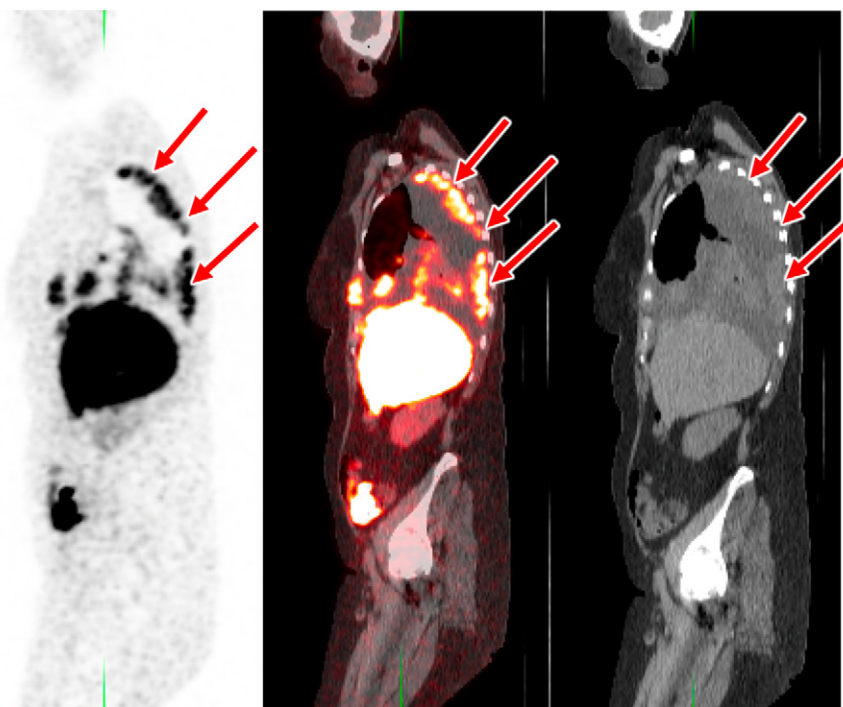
Metastatic ER-positive invasive ductal carcinoma in a 60-year-old woman who underwent mastectomy in 1993 and presented with increased chest discomfort and difficulty breathing in 2019. Sagittal FES PET (left) and fused FES PET/CT (middle) images show FES uptake in right pleural-based metastases (arrows), and sagittal CT image (right) shows a large likely malignant right pleural effusion (SUV scale, 0–5). Subsequent biopsy results of a right lung mass showed ER-positive recurrence. The patient was imaged under a research protocol.
